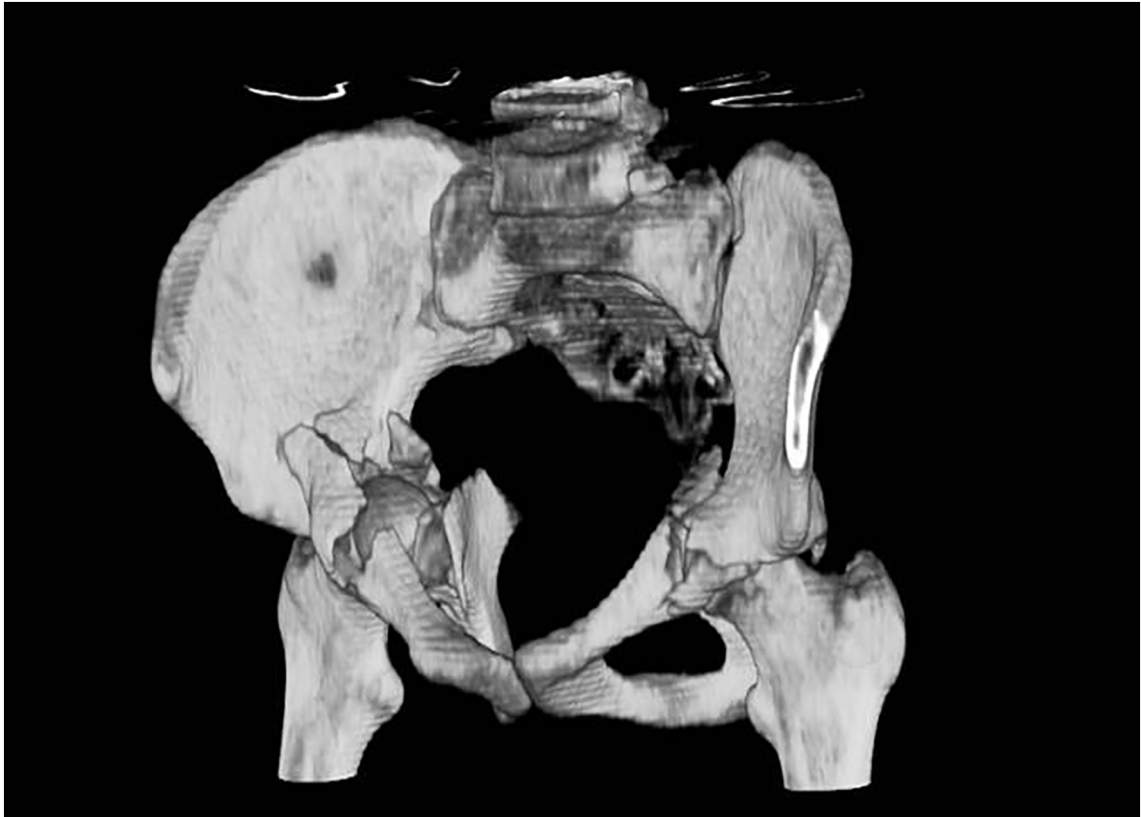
The three dimensional reconstructed computed tomography gave us further details for planning the operation through intrapelvic and exopelvic vision.
